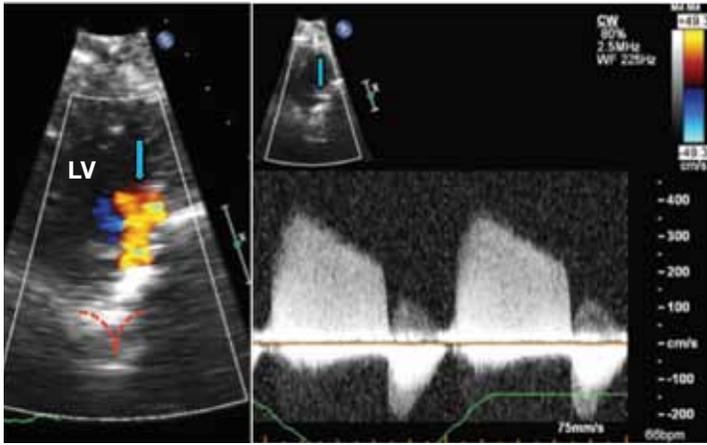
Doppler echocardiography is used to quantify paravalvular regurgitation severity. A deep transgastric TEE view with color Doppler is used to identify the site of regurgitation relative to the prosthetic aortic leaflets (identified in red). Spectral Doppler exam permits quantitative and quantitative assessment of the regurgitant jet (shown with perimeter traced for pressure half-time determination).
